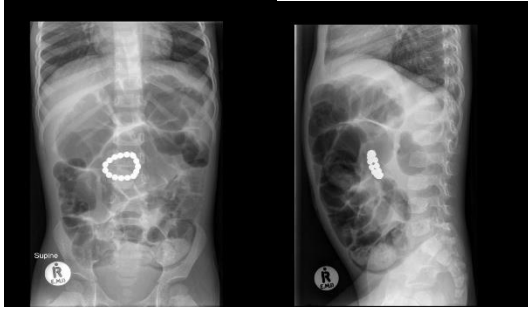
and 1B: Plain abdominal x-ray showing multiple magnets forming a chain.
